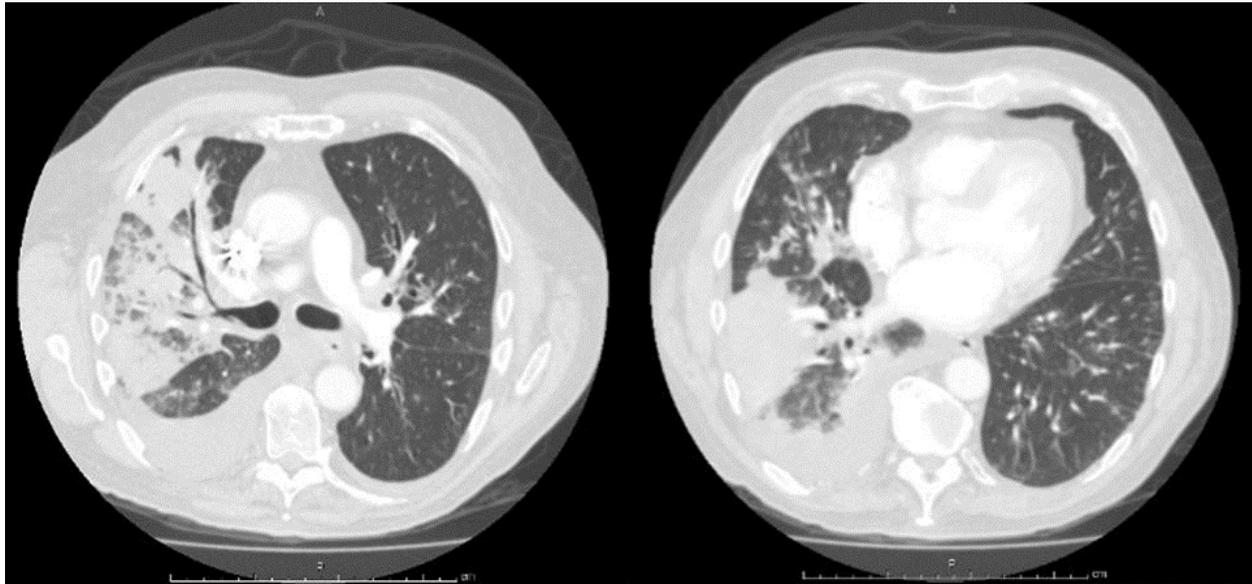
CT angiogram of the chest demonstrating multilobar consolidation of the right lung.
